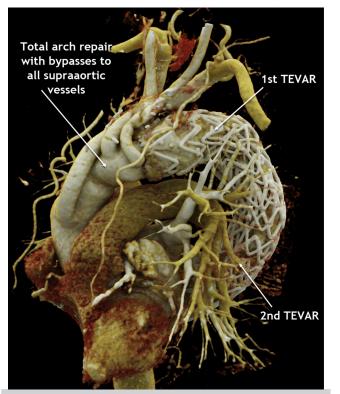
Final three-dimensional reconstruction of computed tomography angiography demonstrating no endoleak.
